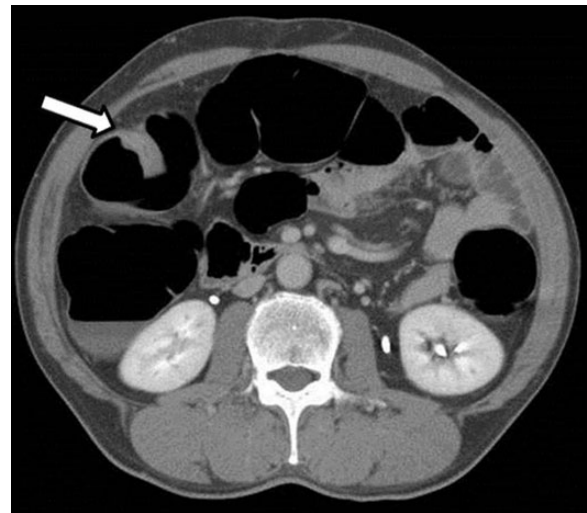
Computed tomography showed the wall thickening of the tumor site (arrow) and no lymph node swelling nor distant metastasis.
